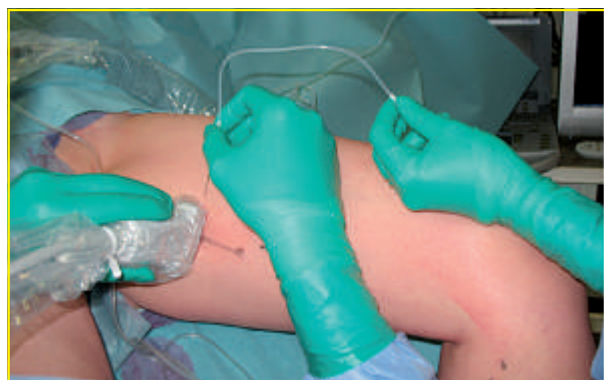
Perpendicular puncture of the venous trunk with transverse ultrasound inspection of the trunk.
